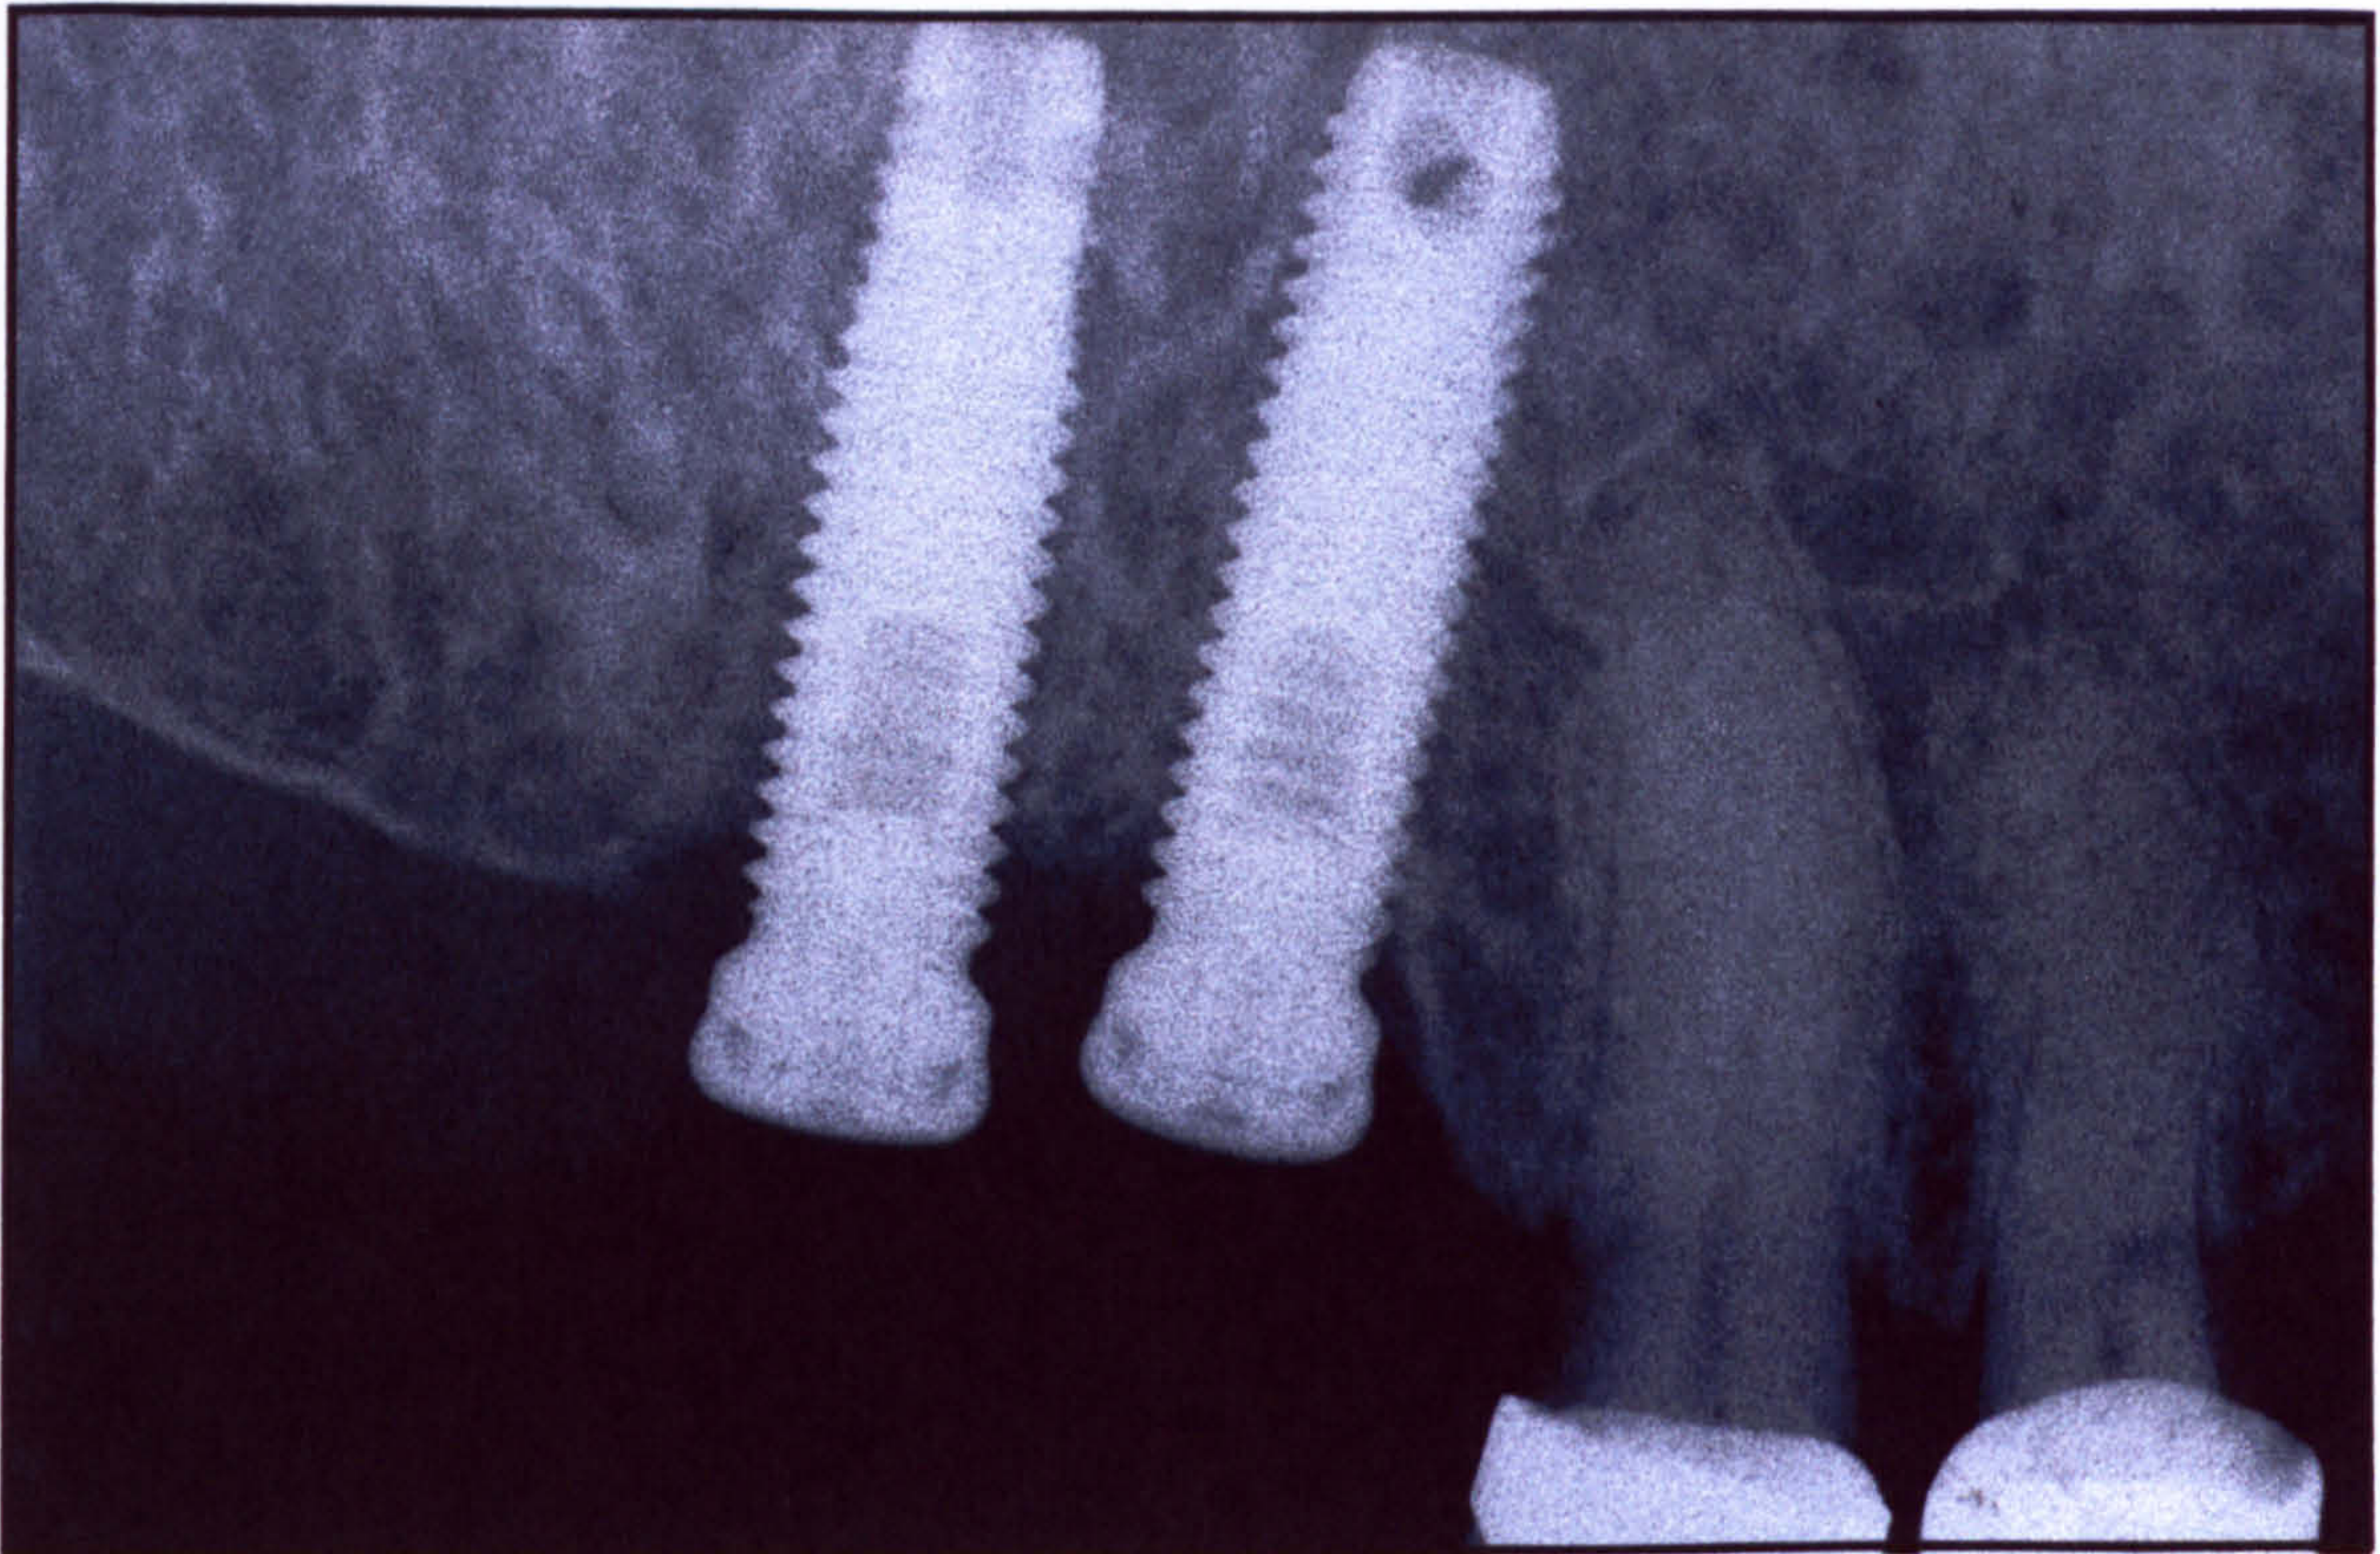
Periapical radiograph of two failing implants.
